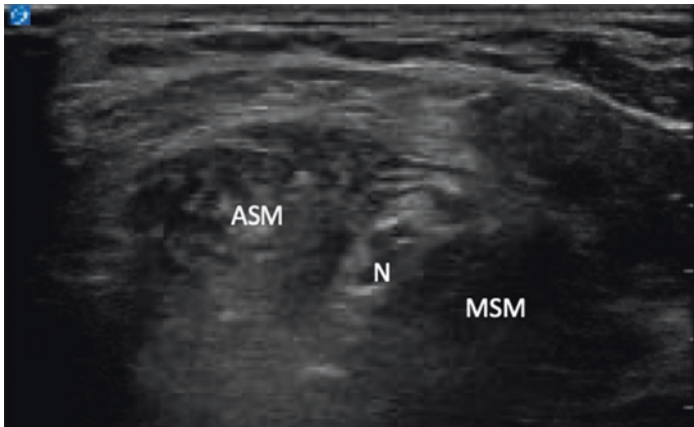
Interscalene block, ultrasound image. ASM anterior scalene muscle, MSM middle scalene muscle, N brachial plexus nerve roots
